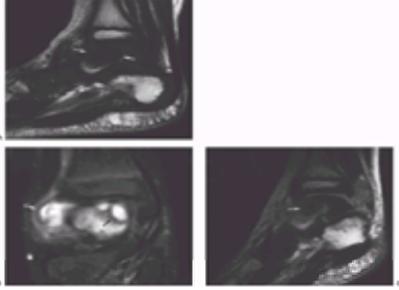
Osteomyelitis of the talus in a 2-year-old boy presenting with foot pain and fever. A: Sagittal T1-weighted image of the foot shows decreased signal intensity in the talus (*arrows*). This reflects marrow edema, and suggests osteomyelitis. B: Coronal fat-suppressed, T2-weighted image of the same ankle shows that there are two discrete areas of higher signal intensity within the talar dome (*black arrow*). The signal of the marrow of the entire talus is abnormal. There is a joint effusion (*white arrow*). C: Sagittal T1-weighted image following the administration of gadolinium shows that most of the talus enhances. The center of the talus, however, does not enhance, indicating a small abscess (*arrow*).
